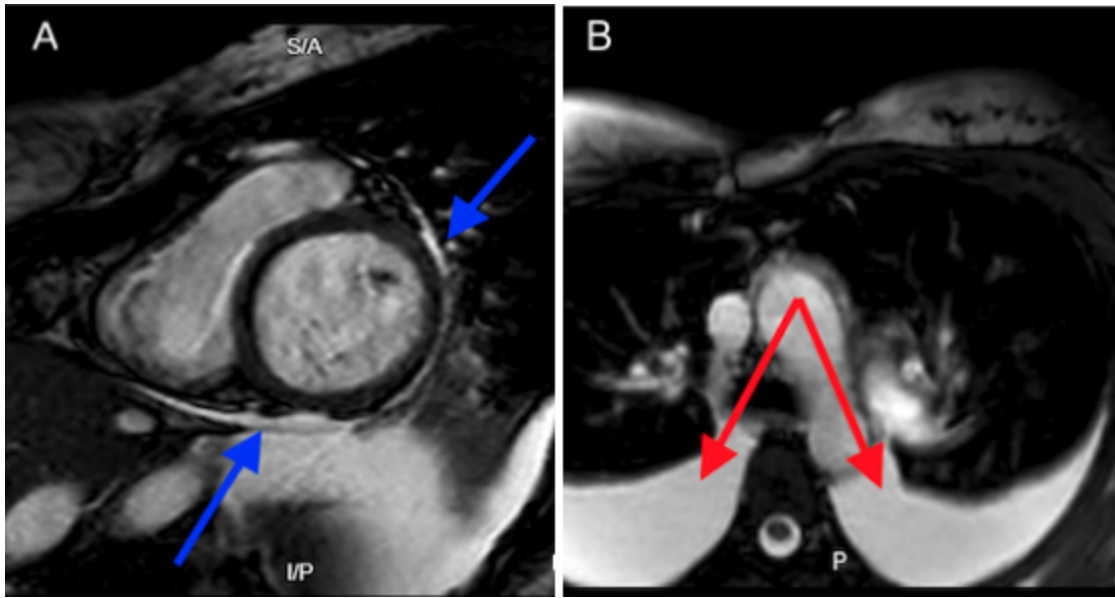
Short axis view on Cardiac MRI with blue arrows indicating trace pericardial effusion.
